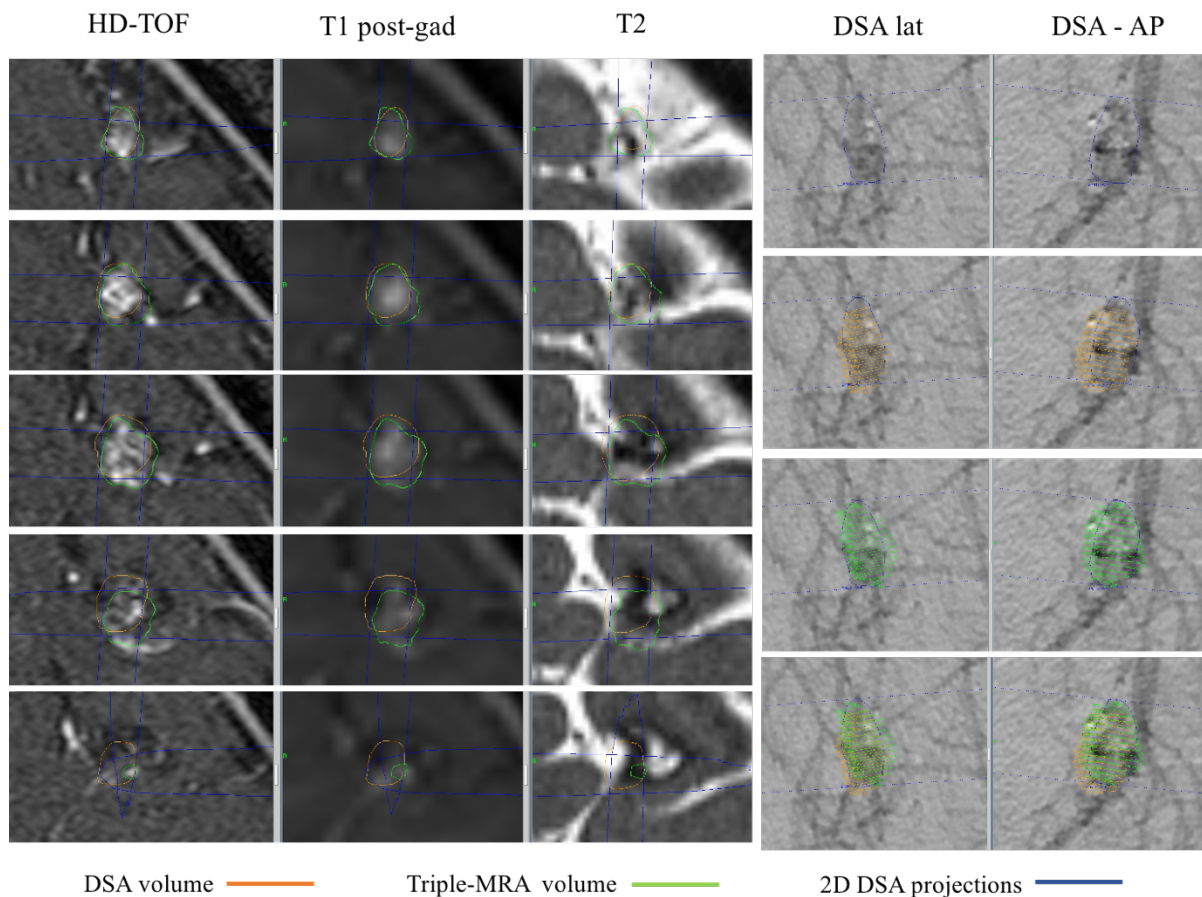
DSA and triple-MRA volumes in the case with the lowest DI and Ccl. The DSA volume (orange) and triple-MRA volume (green) at five representative axial levels of the AVM in case 9 are shown on HD-TOF, T1 post-gad and T2 weighted MRI (first three columns from the left, respectively). The two volumes are also displayed on the lateral and AP projections of DSA (last two columns on the right). Triple-MRA volume seems to be more conformal than DSA volume with the AVM ROI delineated on 2D DSA images (blue contour). During a standard GKR planning session the limits of the AVM ROI delineated on 2D DSA are projected into volumetric MRI scans to define an area within which the AVM is contained.
